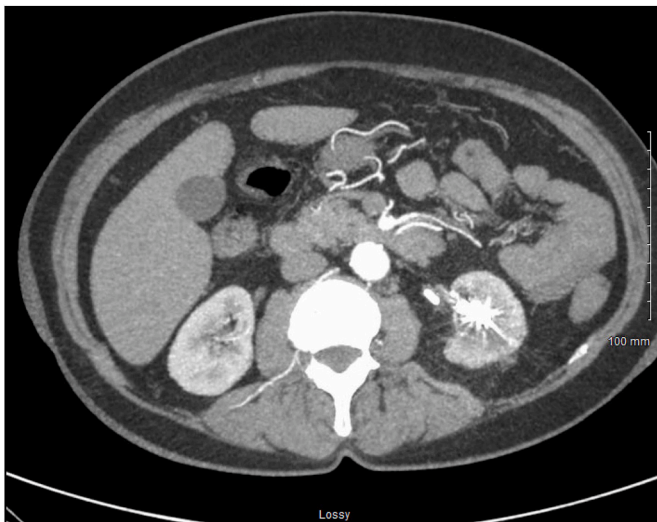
Axial CT angiography showing left renal stone. There is no evidence of coils located within the vasculature.
